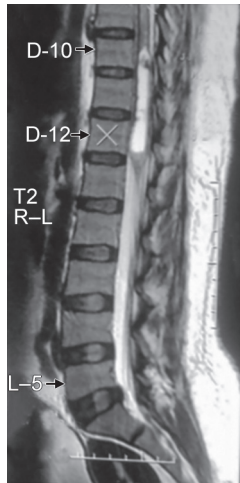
T2-weighted MRI sagittal image
